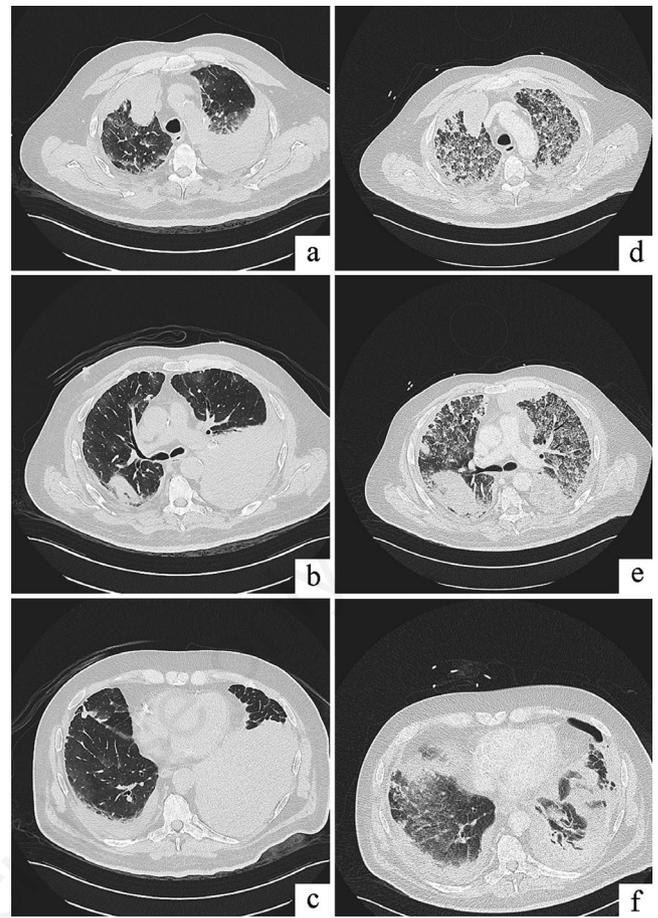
a,b,c) CT scan at the admission shows bilateral hematic pleural effusion and ground-glass alterations. d,e,f) CT scan performed after 6 days reveals increasing ground-glass alterations and bilateral pleural effusion, despite the chest tube.
